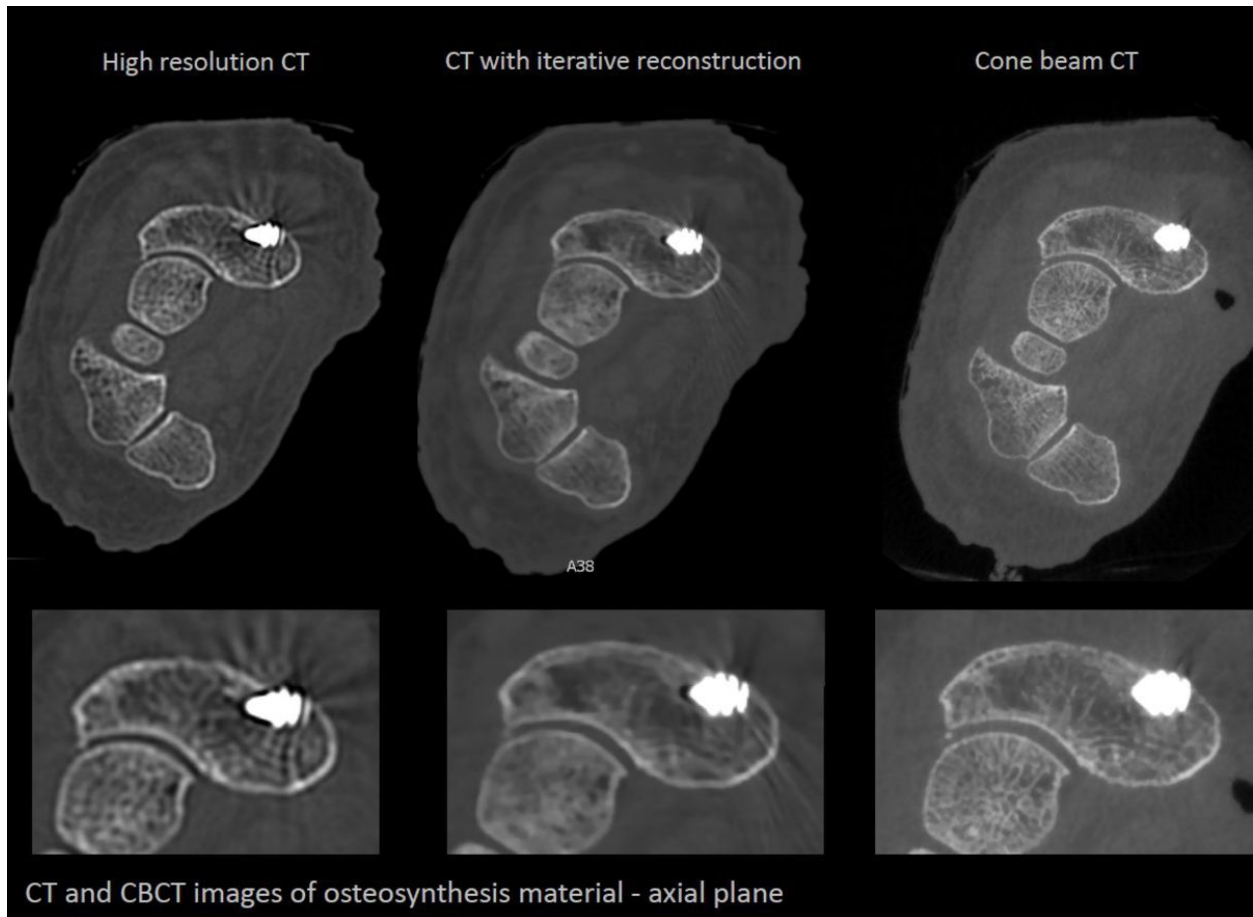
High resolution CT, CT with iterative reconstruction and Conebeam CT images of scafold fracture with Herbert screw fixation.
